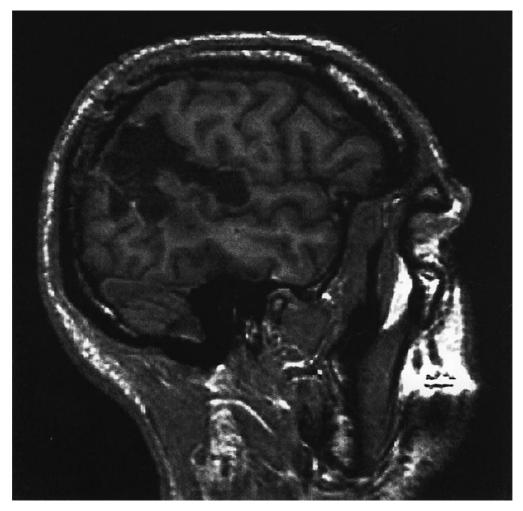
Sagittal view of the MRI of the temporoparietal cortectomy performed in Case 55. Removal of part of areas 22, 42, 39 and 40.
